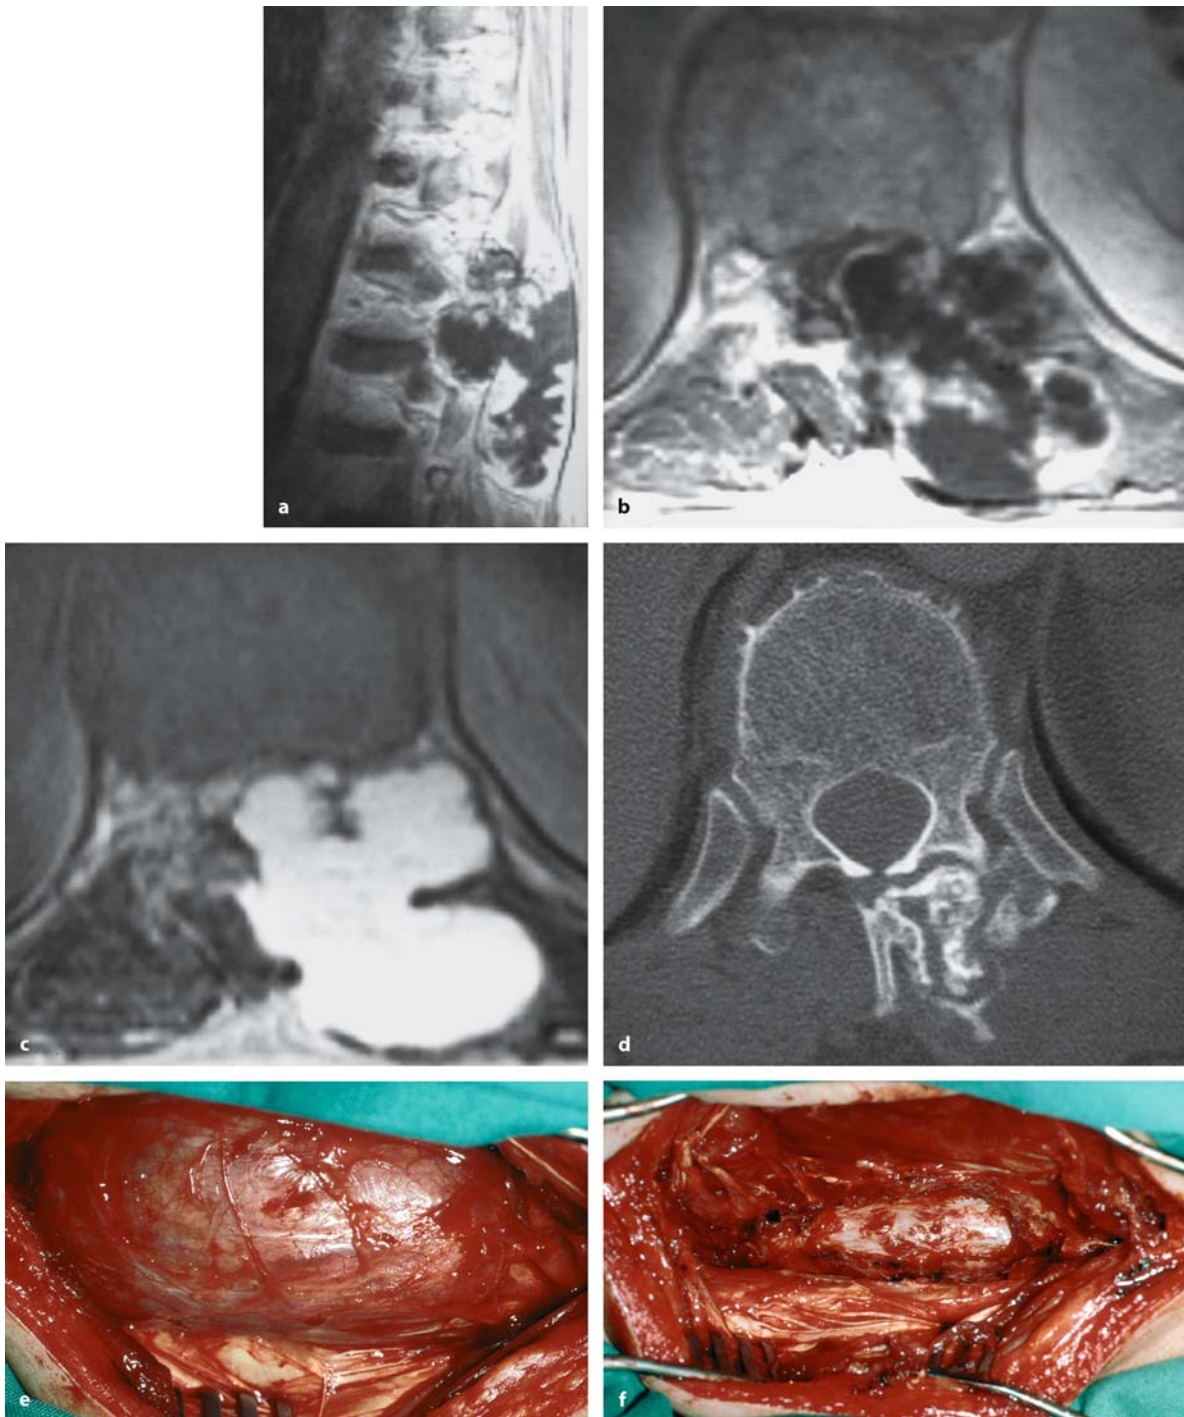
Medial (a) and paramedian (b) sagittal T1-weighted, contrast-enhanced MRI scans of a large chondrosarcoma at Th9–Th10 in a 43-year-old man with a painful swelling in the back and slight sensory changes in his legs. He had undergone two operations for a chondrosarcoma of his 10th rib by thoracic surgeons within the last 10 years. c The considerable extraspinal extension of this mainly cystic-appearing tumor is visible on this axial T1-weighted scan and affects mainly the left side. d The bone-window CT image displays destruction of the left pedicle and the characteristic calcifications (see also Figs. 5.1 and 5.32). e This intraoperative view demonstrates the huge tumor after soft-tissue dissection. (Continuation see next page)
